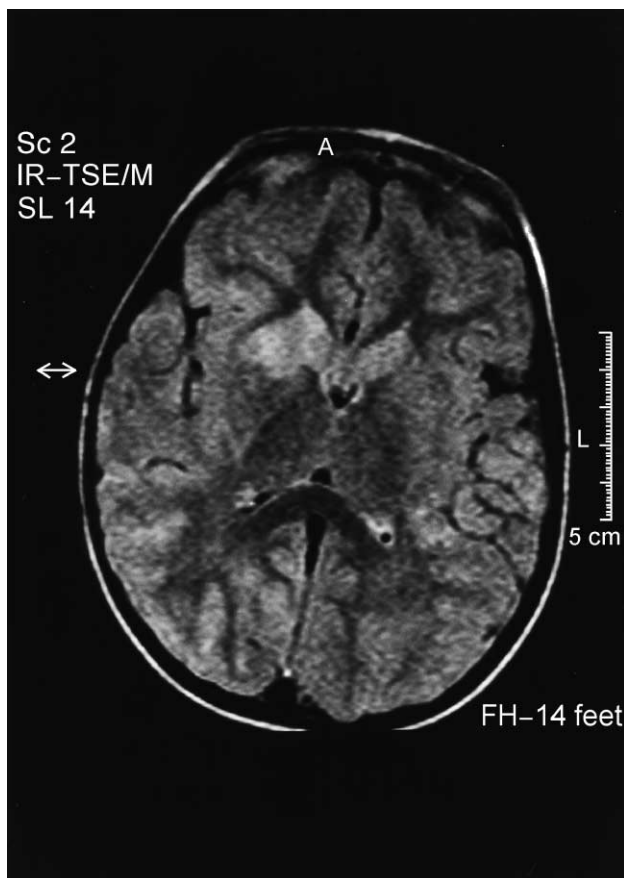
MRI image of Patient 1 (T2-weighted FLAIR) showing high signal intense lesions within the right nucleus lentiformis, both caudate nuclei and the right parietal gyri 3 days after admission. Native and contrast-enhanced T1-weighted images were normal.
